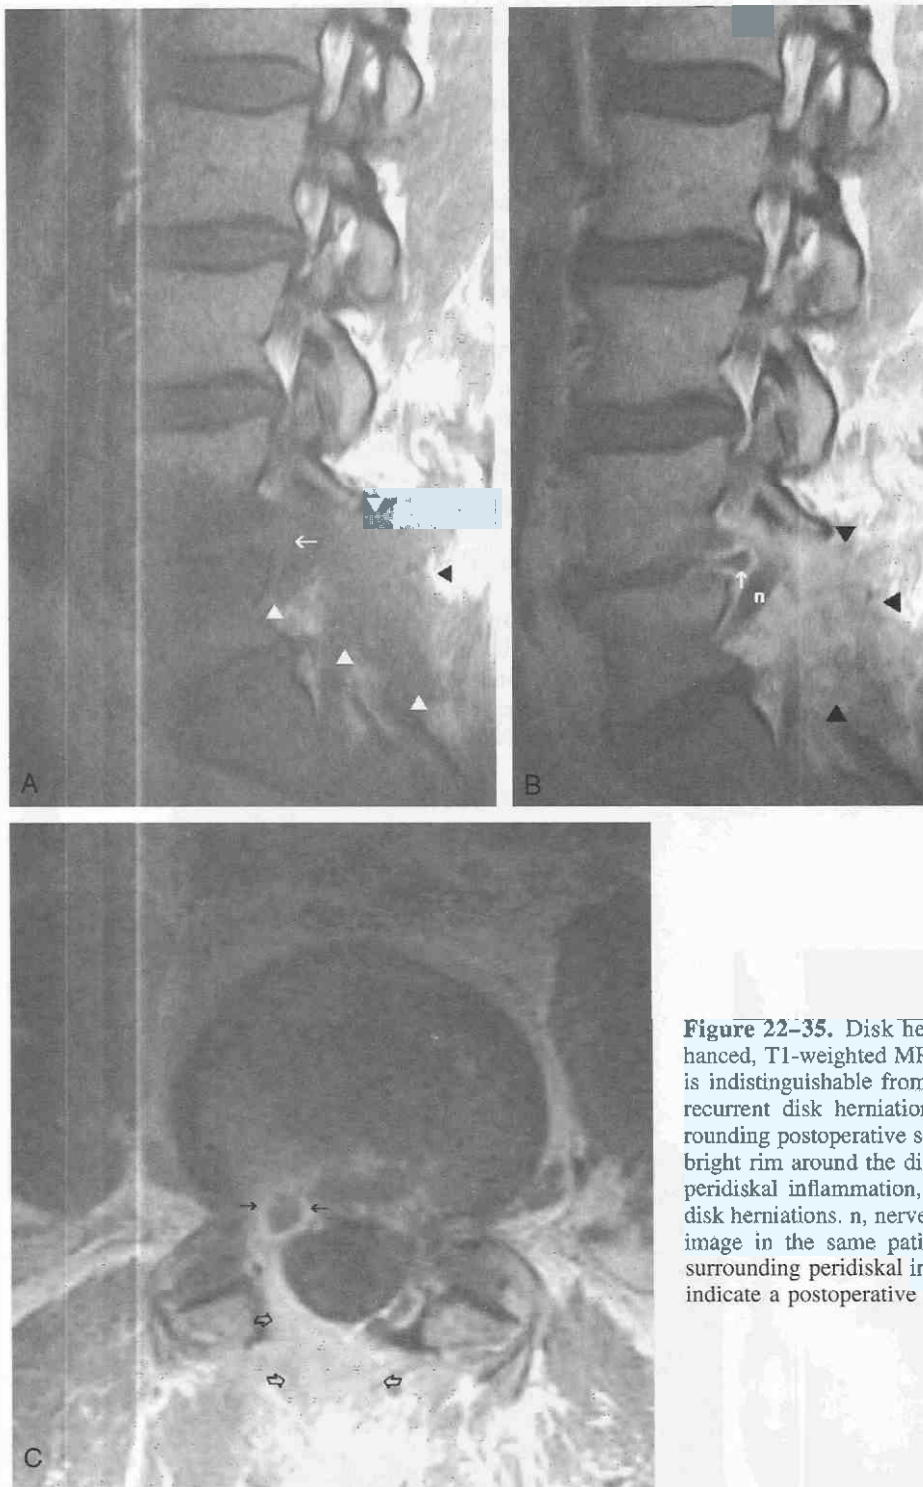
Disk herniation. *A*, Postoperative sagittal unenhanced, T1-weighted MR image. Recurrent disk herniation (arrow) is indistinguishable from scarring (arrowheads). *B*, Nonenhancing recurrent disk herniation (arrow) now stands out from the surrounding postoperative scar (arrowheads). The intensely enhancing bright rim around the disk is not a postoperative scar but, instead, peridiskal inflammation, which can be seen even on nonoperated disk herniations. *n*, nerve root. *C*, Axial enhanced T1-weighted MR image in the same patient shows recurrent disk herniation with surrounding peridiskal inflammation (closed arrows). Open arrows indicate a postoperative scar.
